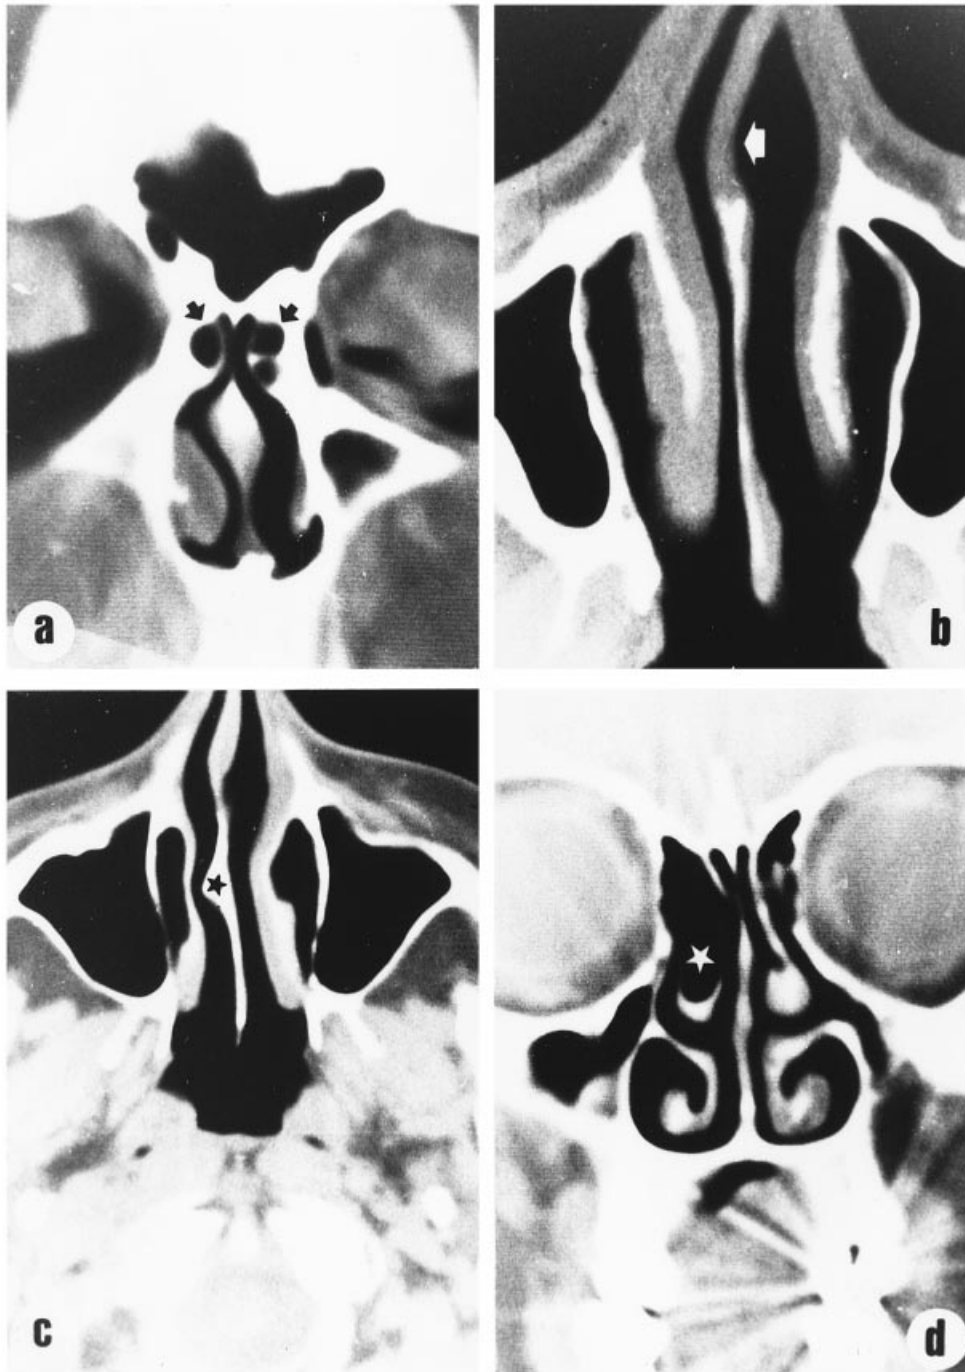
CT images of some of the nasal sinus anatomical variants observed. (a) Coronal scan; agger nasi air cells (arrows); (b) horizontal scan; deviation of the nasal septum (arrow); (c) horizontal canal; bony spur of the nasal septum (black star); (d) coronal scan; concha bullosa (white star).
